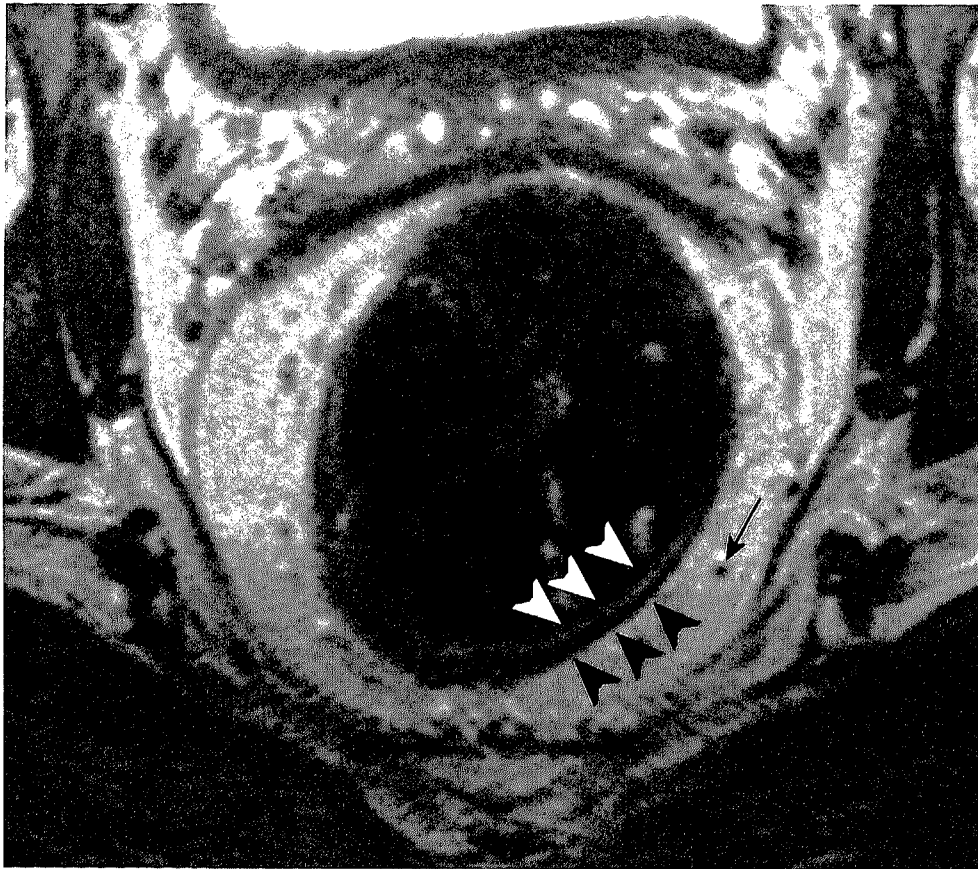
Axial T2W FSE (TR/TE 5312/150 msec) MR image shows the inner layer of the rectal wall, as a line of intermediate signal intensity relative to muscle tissue representing the mucosa (white arrowheads). The outside layer of the rectal wall, a hypo-intensity line, corresponds to the muscularis propria recti (black arrowheads). A small lymph node is visible as low intensity round structure (black arrow).
